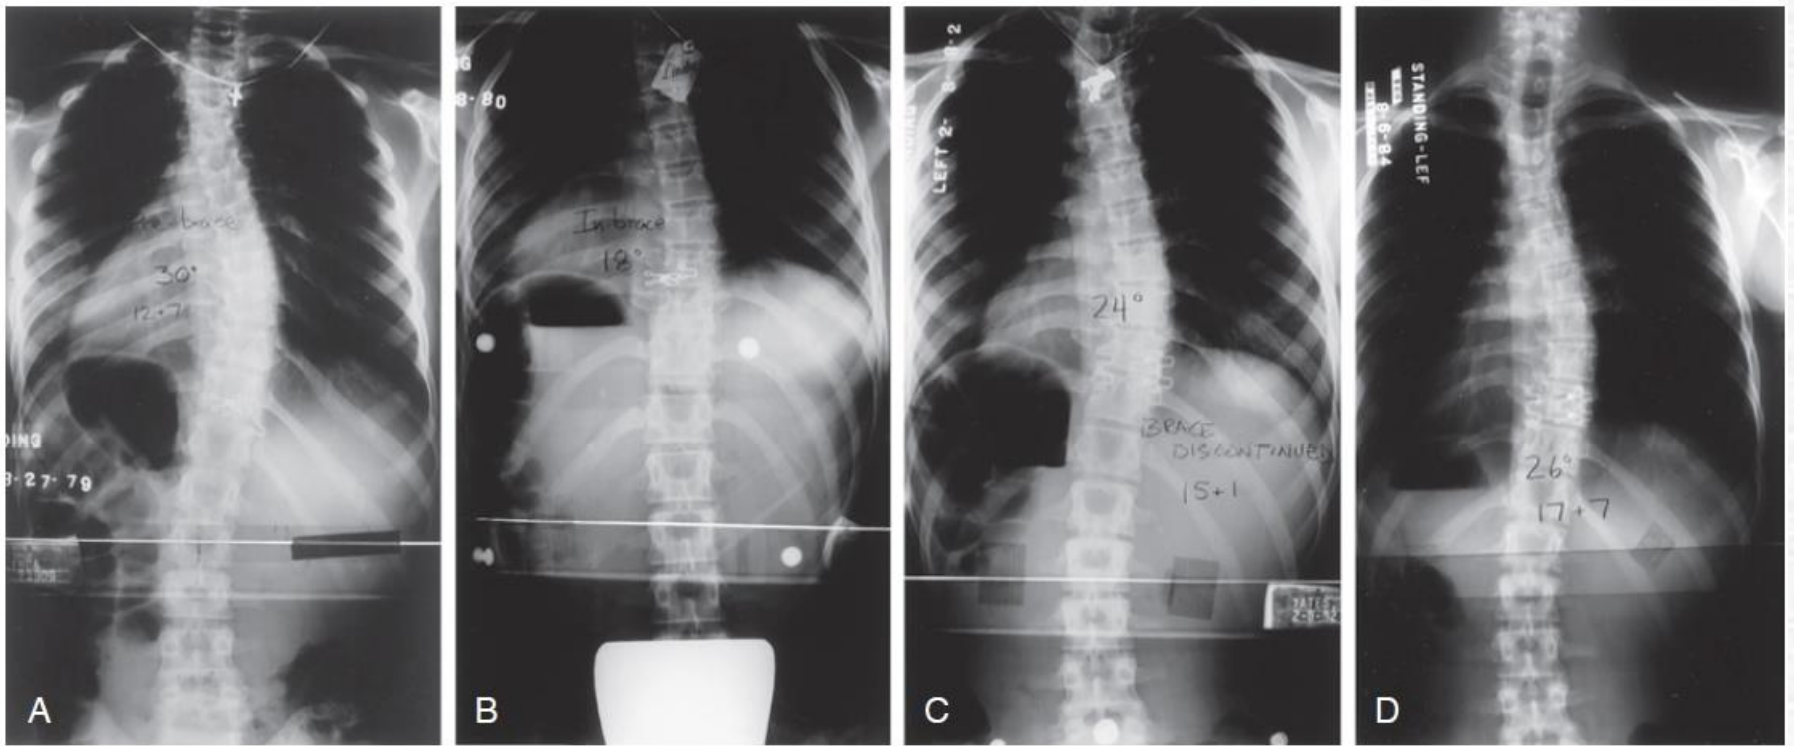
Radiographic findings with brace wear. A, Initially, this premenarchal girl aged 12 years 7 months had a 30-degree thoracic curve and was Risser grade 0. B, Treatment in a Boston brace was begun, with in-brace correction to 18 degrees. C, Brace wear was continued until the patient was 2 years postmenarchal and Risser grade 4. D, Thirty months later, the curve remained stable at 26 degrees.
